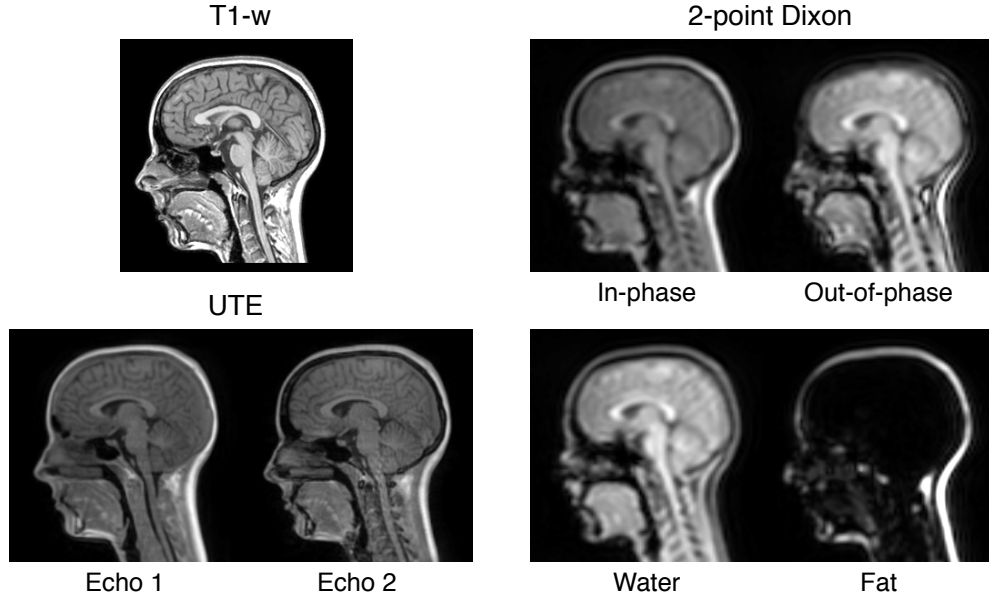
Example of MRI sequences used to derive attenuation maps. Top left: T1-weighted. Bottom left: ultrashort echo time (UTE). Right: 2-point Dixon.
